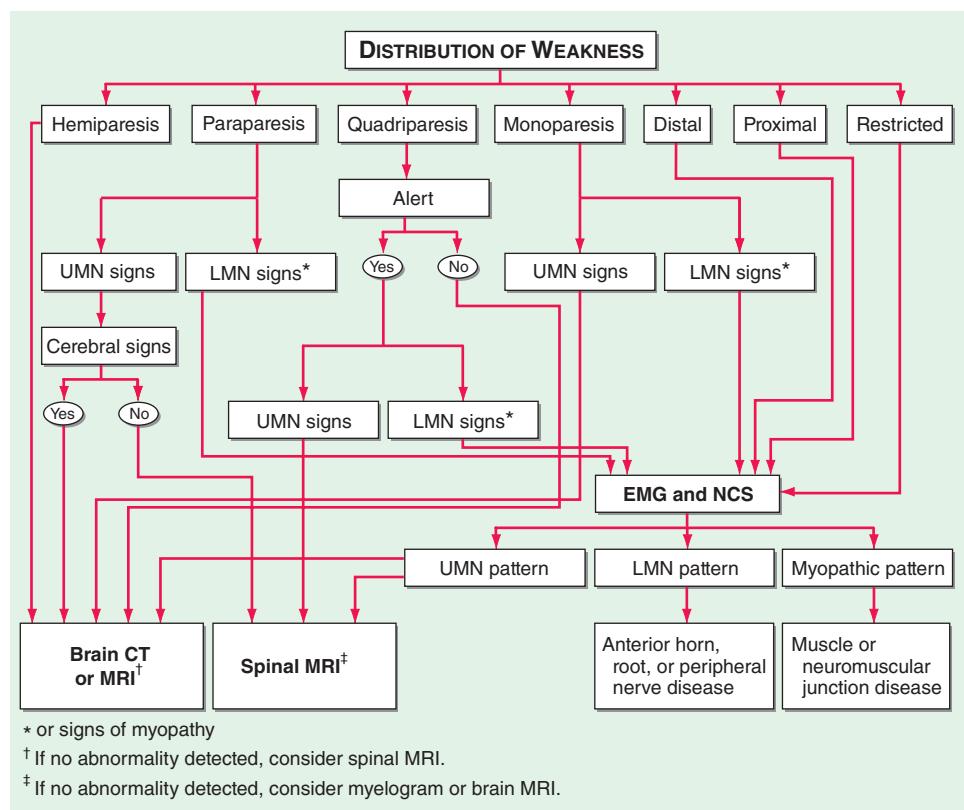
An algorithm for the initial workup of a patient with weakness. CT, computed tomography; EMG, electromyography; LMN, lower motor neuron; MRI, magnetic resonance imaging; NCS, nerve conduction studies; UMN, upper motor neuron.
